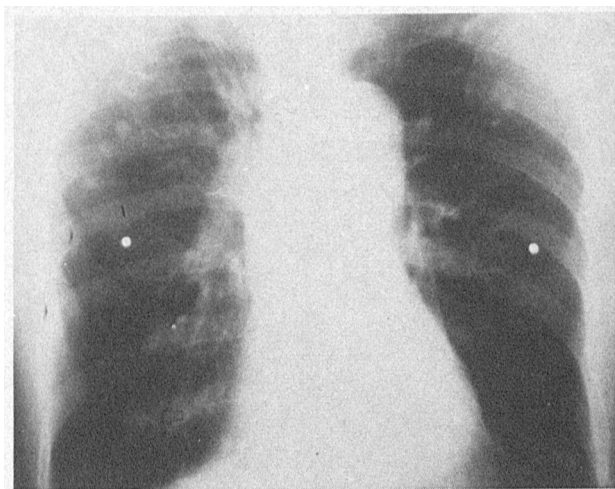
Repeat Radiograph with Arms Extended over Head, Showing Nipple Marker Clearly Separable from Lesion (Arrow).
